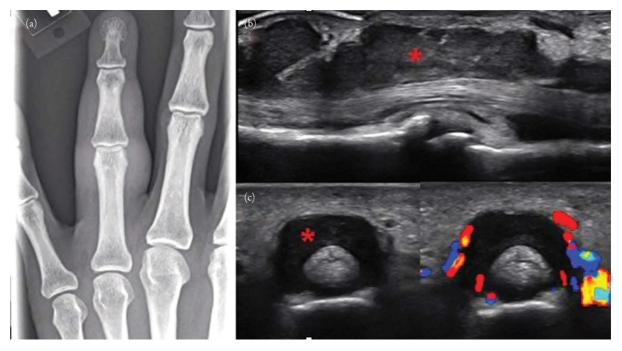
Finger Tenosynovitis. Panel (a) is a plain radiograph showing diffuse 4th finger soft tissue swelling. Panels (b) and (c), respectively, show long and short axis ultrasound images of the volar 4th finger at the proximal interphalangeal joint level with severe expansion of the flexor tendon sheath with echogenic material (*) consistent with a complex tenosynovitis. Panel (c) also shows a transverse color Doppler image with increased flow along the periphery of the tendon sheath suggesting hyperemia and possible active inflammation.
